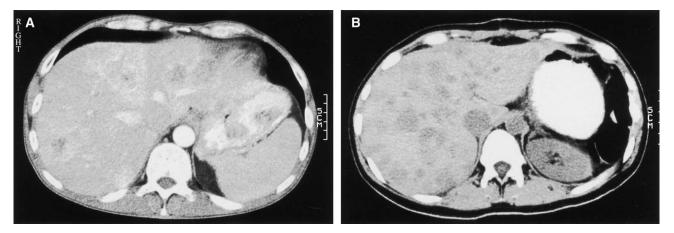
(A) Preoperative contrast-enhanced computed tomographic scan of the liver in a 36-year-old man with four bilobar metastases that were confirmed by intraoperative ultrasound. This patient underwent left lobectomy combined with wedge resection and radiofrequency ablation of metastatic deposits in segments 5 and 6, respectively. (B) A patient with unresectable liver metastases from a glucagonoma, who was treated with palliative distal pancreatic resection in an attempt to control neuroendocrine symptoms.
